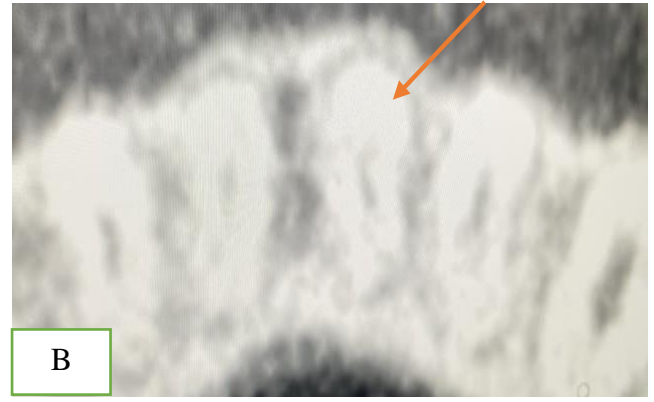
Cone-beam computed tomography images of a mandibular central incisor showing Type I Vertucci classification of canal morphology (1-1) in the axial plane: (a) single canal at the coronal third, (b) 1 canal at the middle third, (c) single canal at the apical third. (D) coronal plane
